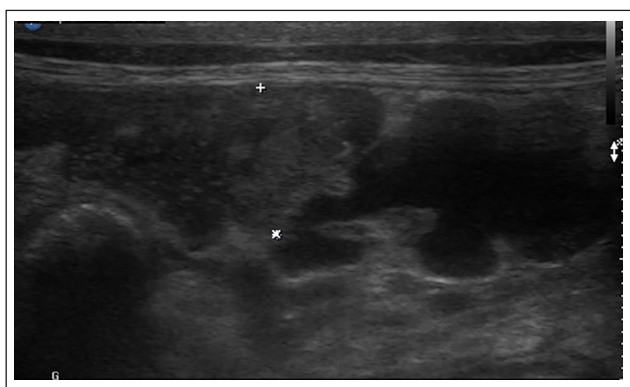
Ultrasound image of the pancreas
